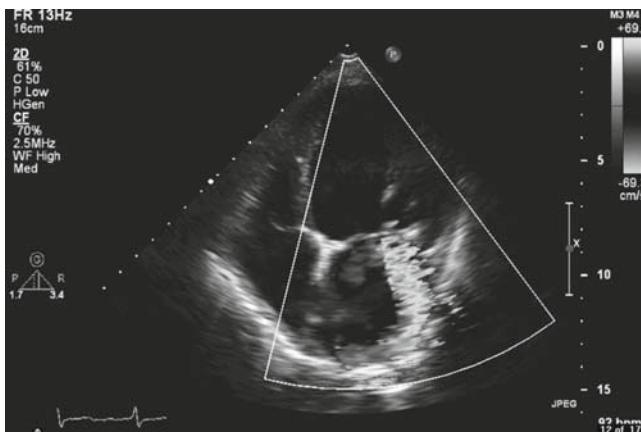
Preoperative color Doppler echocardiography. The direction of the regurgitant jet suggested a prolapse of the anterior leaflet
